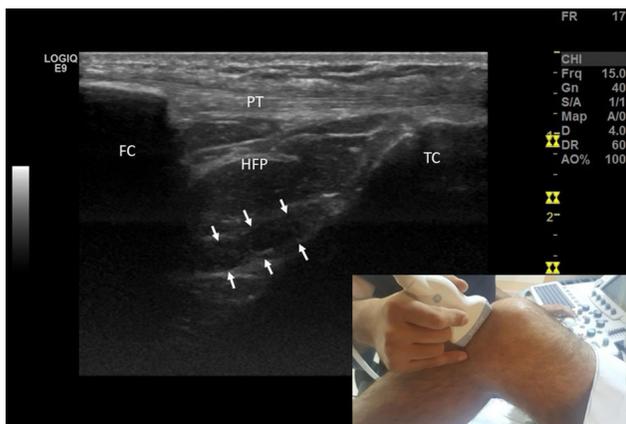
Longitudinal grayscale ultrasound image of the anterior cruciate ligament. The small inset image demonstrates the anatomical orientation of the transducer and knee position (FC: femoral condyle, TC: tibial condyle, PT: patellar tendon, HFP: Hoffa's fat pad).
